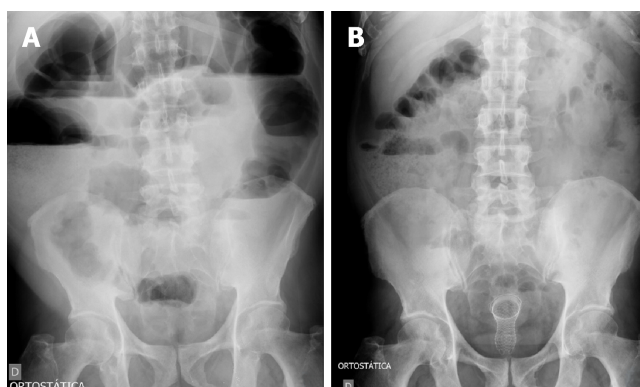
Radiography images. A: Radiography showing signs of a distal obstruction; B: Radiography of the same patient showing improvement after stenting and decompression. Figure 4 Stents procedure. A: Guide-wire placement through the stricture after contrast study; B: Stent deploying through the scope; C: Stent placement showing the stricture in the middle of the stent; D: Final stent position.
